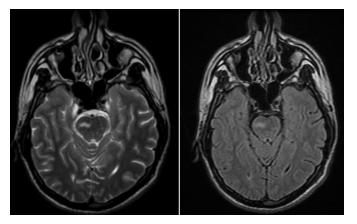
Abnormal T2WI/FLAIR Hyperintense Signals Seen in the Right Pons.
